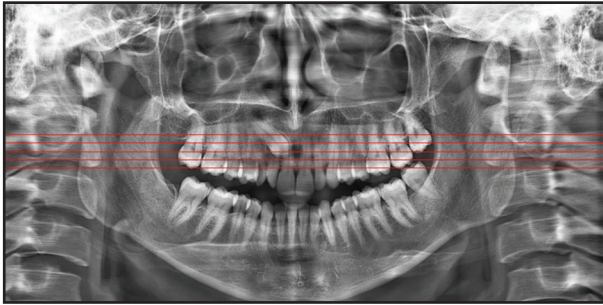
Panoramic radiograph showing Horizontal sectors
